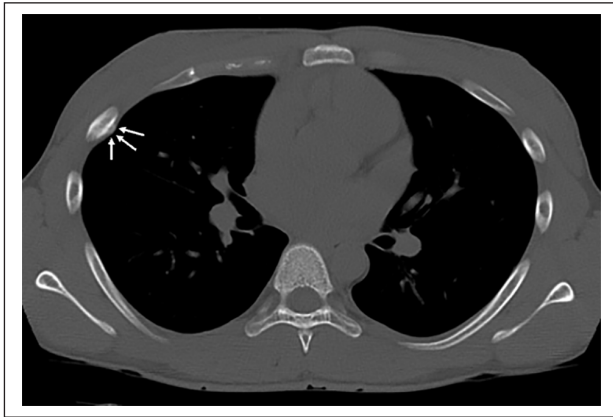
Fracture of the right fifth rib with predominant callus formation on the pleural side (arrows) on chest computed tomography.
